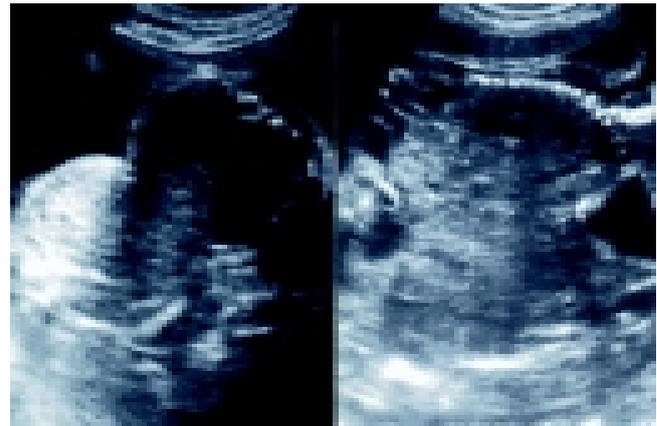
Case 2 :Ultrasound shows thoraco-omphalophagus types of conjoined twins.
